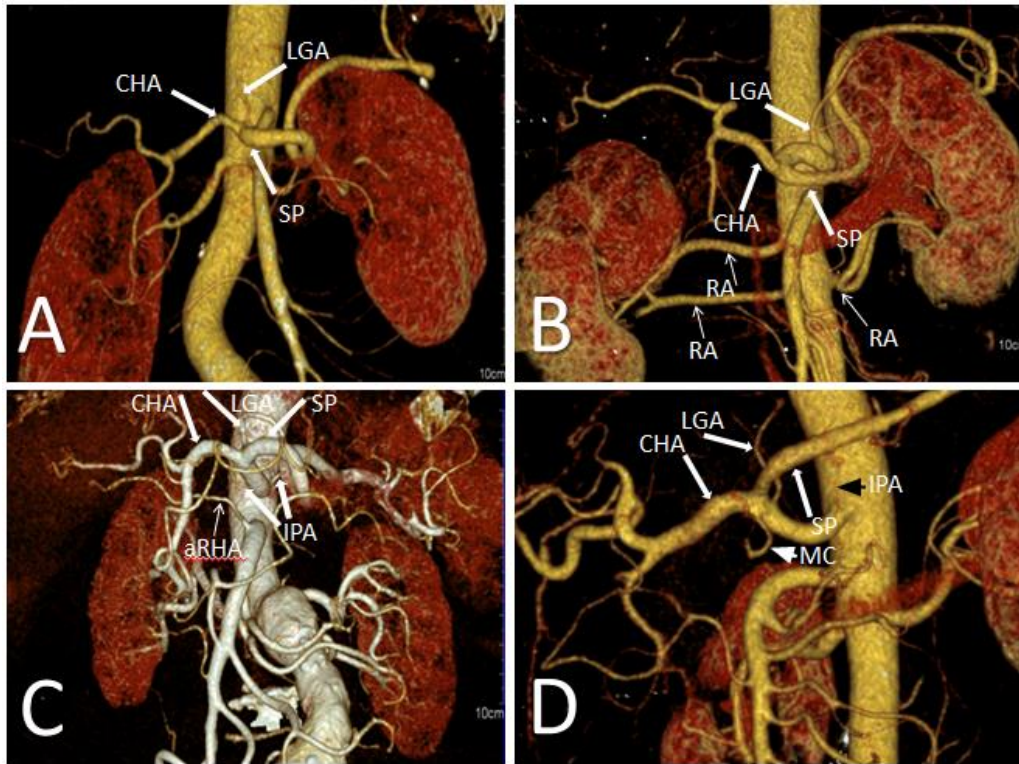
3D VR images (A and B) show normal trifurcation of the CT into CHA, LGA and SP (Uflacker's type I). (A) Classic trifurcation. (B) Non-classic trifurcation where the LGA originates from the CT and then it bifurcates into CHA and SP. Notice the double renal arteries. (C and D) show penta-furcation of the CT. (C) Show both IPA arise from the CT. Notice the accessory right hepatic artery from the SMA. (D) Depicts left IPA and middle colic arteries originate for the celiac trunk. CHA (Common hepatic artery), LGA (Left gastric artery), SP (Splenic artery), RA (Renal artery), IPA (Inferior phrenic artery), aRHA (accessory right hepatic artery), MD (Mid colic artery).
